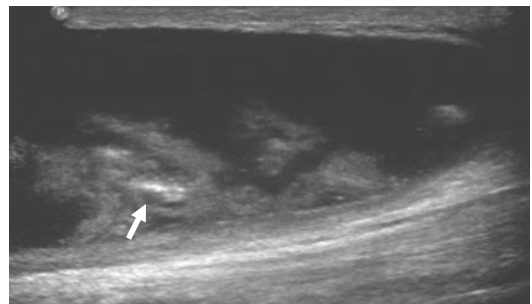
Tuberculous spondylodiscitis of the thoracic spine. Ultrasound image shows a large soft tissue abscess surrounded by a thin and smooth wall and containing thin calcifications (arrow)
